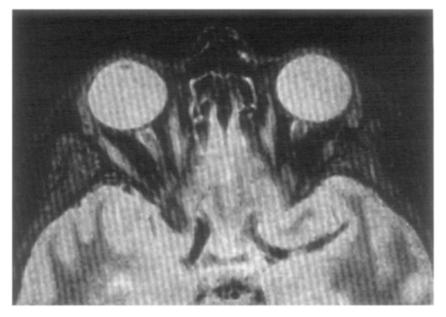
MR image after gadolinium injection shows enhancement of the right optic nerve in a patient with new-onset optic neuritis.
